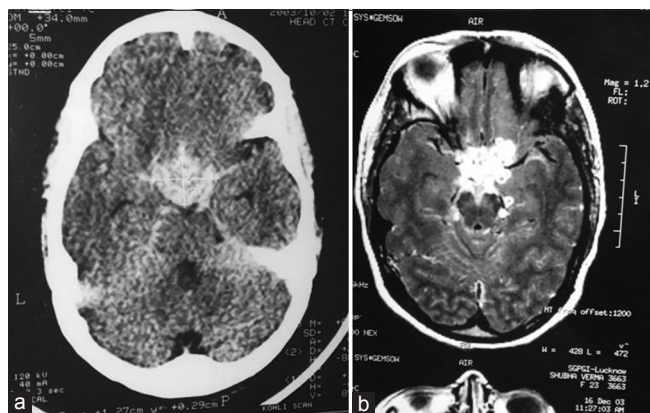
(a) CT scan brain showing pituitary mass. (b) MRI brain showing Tuberculoma postoperatively
